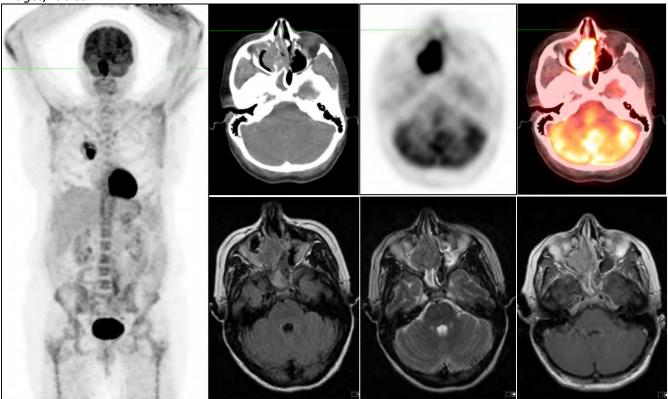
Right sinonasal squamous cell carcinoma. A 44 y.o. female with history of right upper lobe mass was referred for F-18 FDG PET CT scan. There was a hypermetabolic right upper lobe mass, which was pathologically proven high-grade spindle and giant cell carcinoma. Synchronously, there was a hypermetabolic soft tissue mass (SUV max 13.2) centered in the right nasal cavity extending to the medial aspect of the right maxillary sinus. The lesion extended from the floor of the right nasal cavity potentially into the left posterior ethmoid sinus. There was opacification of right sphenoethmoidal recess, right posterior ethmoid and sphenoid sinuses. There was destruction of the posterolateral wall of the right maxillary sinus with extension of tumor into the pterygopalatine foramen with involvement of the sphenopalatine foramen. There was destruction of the osseous posterior nasal septum, posterior medial maxillary sinus, floor of the right ethmoid sinus and posterior lamina papyracea and nasal turbinates. Periosteal thickening of the right sphenoid sinus is seen and to a lesser extent involving the maxillary sinus consistent with an element of chronic sinusitis. MRI showed a lobulated T1 isointense, T2 isointense, enhancing soft tissue mass in the right nasal cavity and right ethmoid sinus. There was also mucosal thickening in the right maxillary sinus, left sphenoid sinus, with fluid collection in the maxillary sinuses and complete obliteration of the right sphenoid sinus. The patient underwent nasal endoscopy and maxillary anterostomy, the pathology revealed squamous cell carcinoma.
